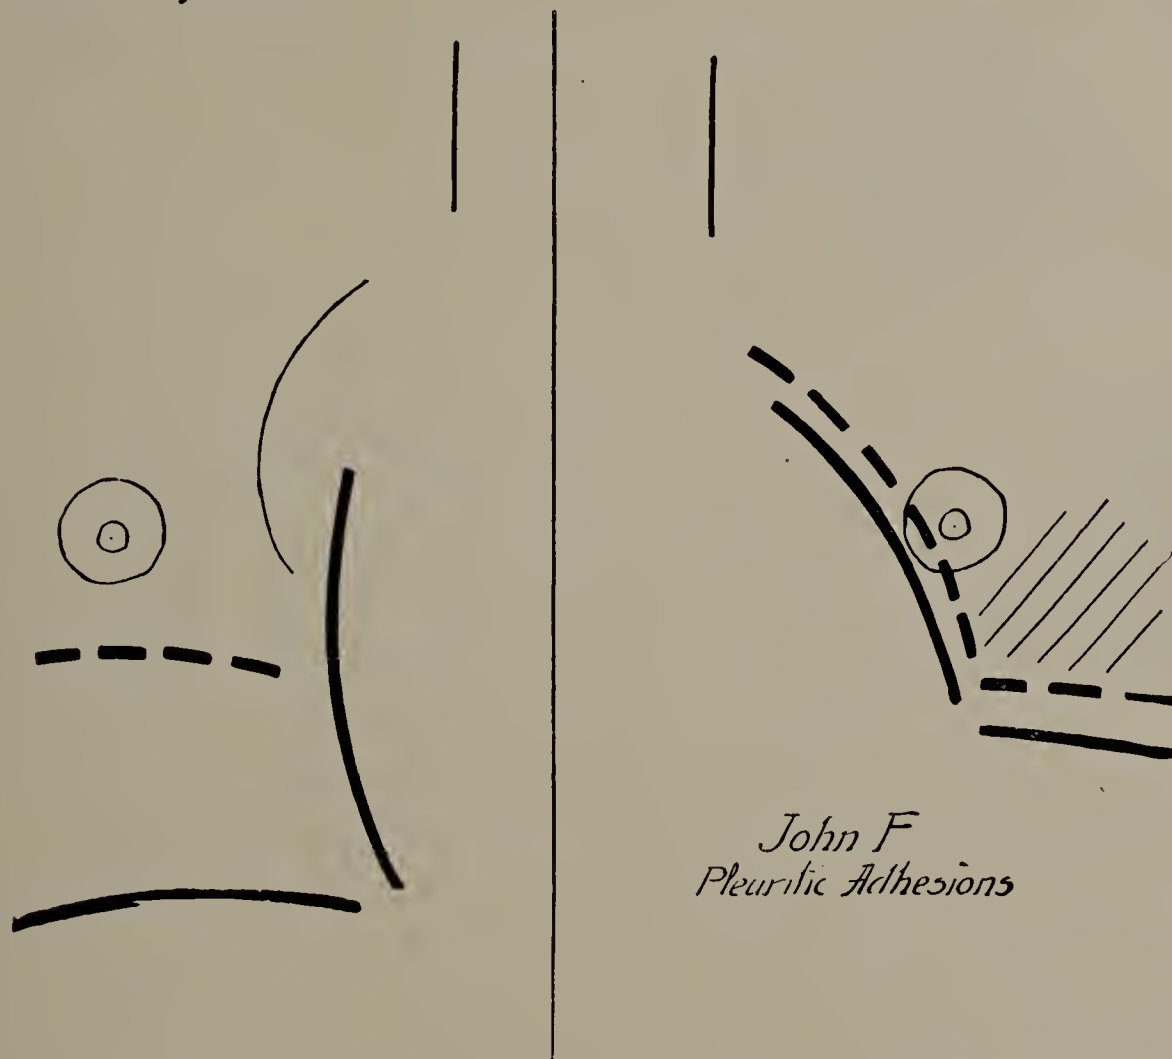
John F. April 13, 1899. Cut of X-ray tracing (one-third life size). Pleuritic adhesions on left side, indicated by the restricted movement of the diaphragm and heart on that side. The darkened area at the lower part of the lung may be due to thickened membrane, though to cast a perceptible shadow it would have to be exceedingly thick or calcified.
